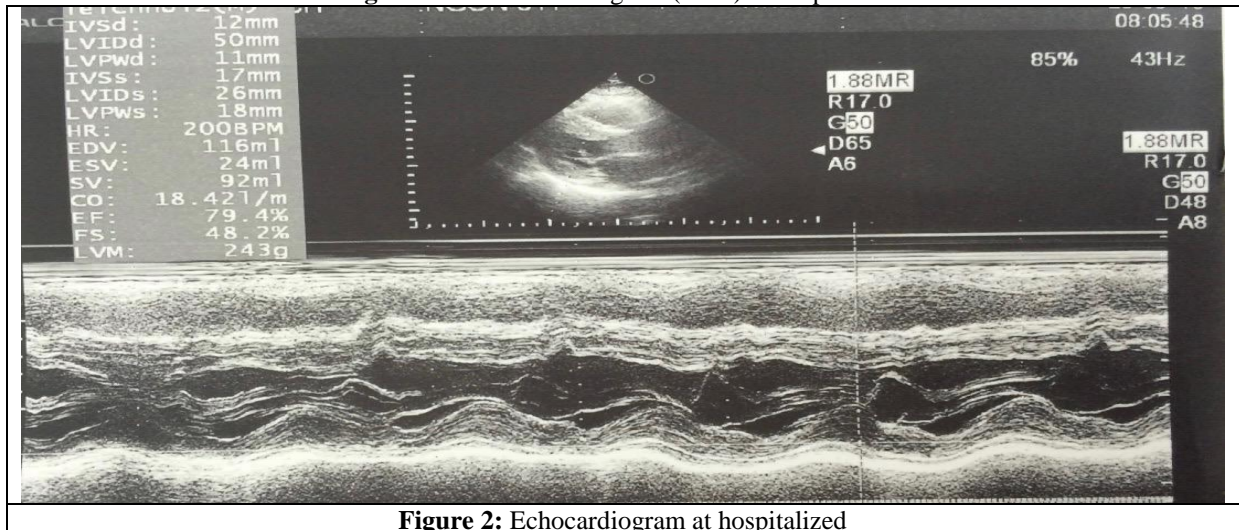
Echocardiogram at hospitalized
